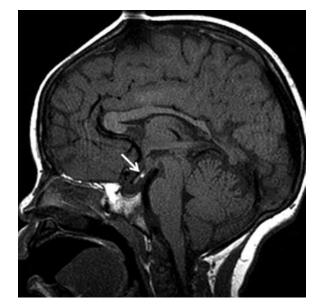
Three-year-old patient presenting with pituitary dysfunction: Panhypopituitarism. Sagittal midline T_1 MR image delineates a "bright spot," the posterior pituitary/neurohypophysis, not in the posterior aspect of the sella as expected but just posterior to the chiasm at the expected location of the proximal stalk *(arrow).* The stalk is absent and the pituitary gland is small, indicating ectopic posterior pituitary with interruption of the stalk. Thinning of the posterior aspect of the corpus callosum is related to periventricular leukomalacia in this patient, who was premature.
